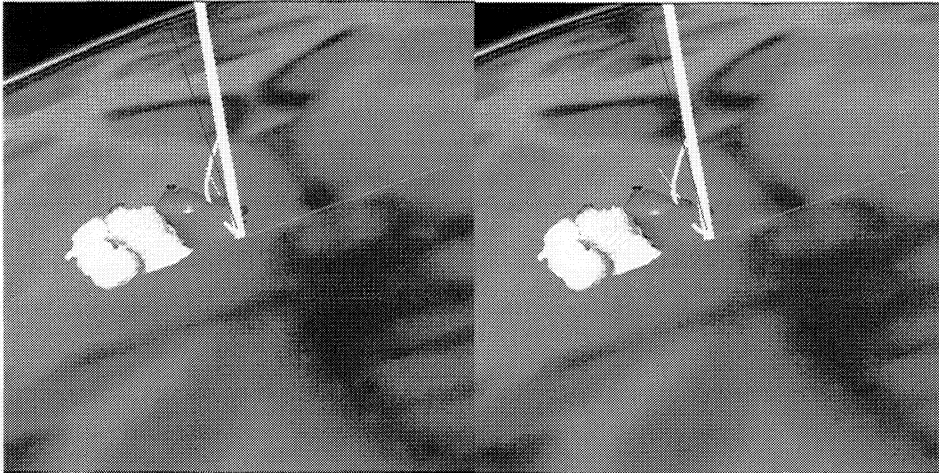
Stereoscopic view (set for cross-eye viewing) of nuclei within the 3-D atlas volume integrated with a texture map of MRI intensity values, and leukatome surgical tool.
